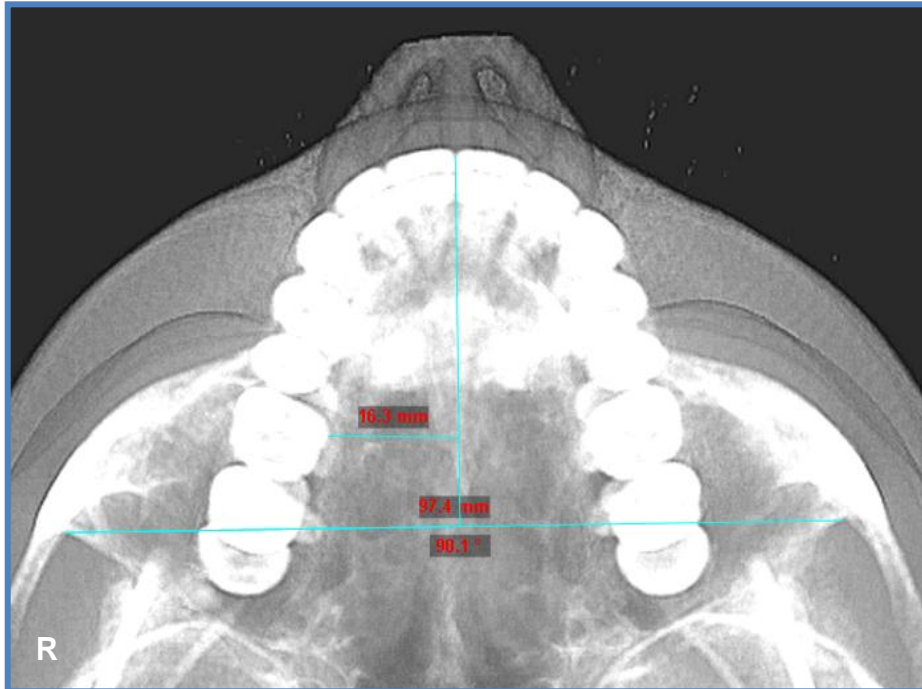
Example of an occlusal plane measure for the sub-mental view. Some reference lines can be seen in this image as were used to locate the point equidistant between the molars, and to the anterior most point of the zygomatic arch depressions. The angular measure originating between the central incisors and terminating at right zygomatic arch can also be seen. This image is from a final CBCT after removal of appliances.
